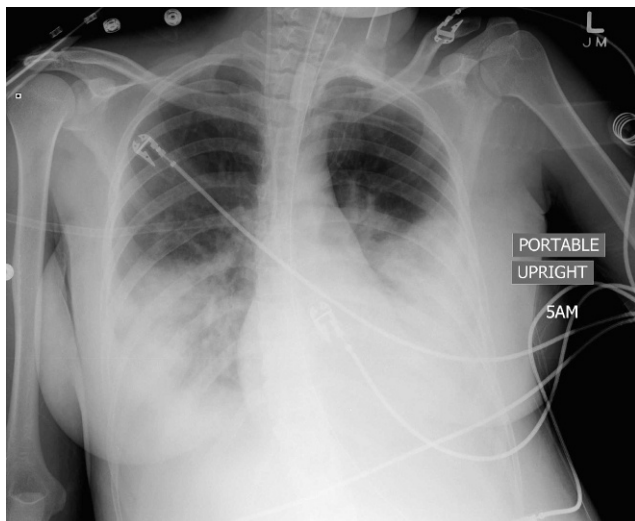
Chest radiograph revealing bilateral blunting of the costophrenic angles with prominent pulmonary vessels along the left heart border, indicative of pulmonary hypertension.
